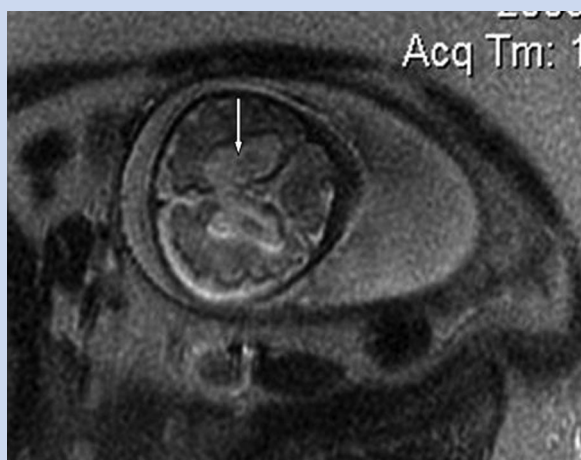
Fetal MRI, 29 weeks of gestation showing ventriculomegaly [arrow].
